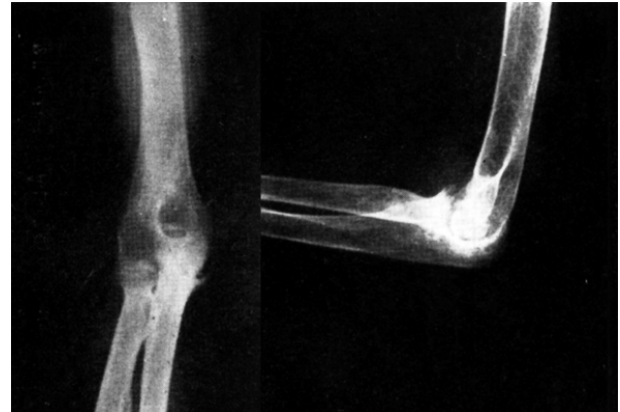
The X-ray of the left elbow
